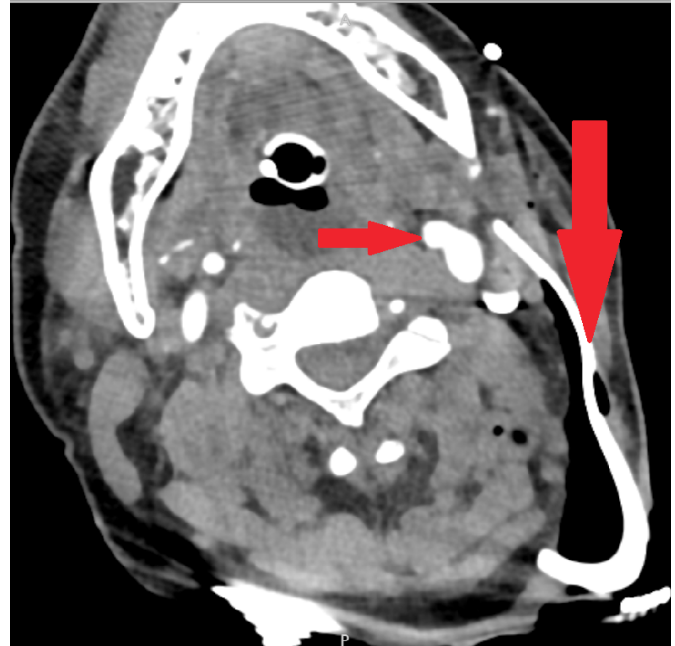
CT angiography of the head and neck demonstrating foreign body abutting major vasculature.
